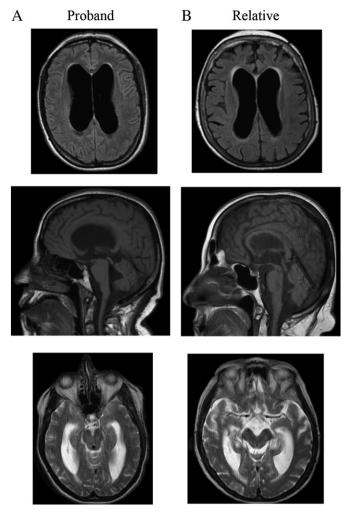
Case report pre-operative imaging. A) Proband MRI demonstrating communicating ventriculomegaly with a flow void in the cerebral aqueduct. B) Relative MRI demonstrating communicating ventriculomegaly with a flow void in the cerebral aqueduct.
